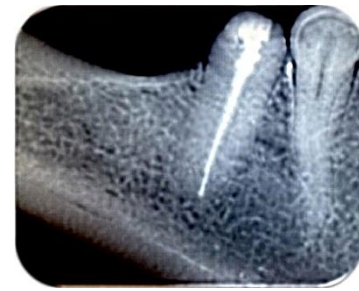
Periapical image
